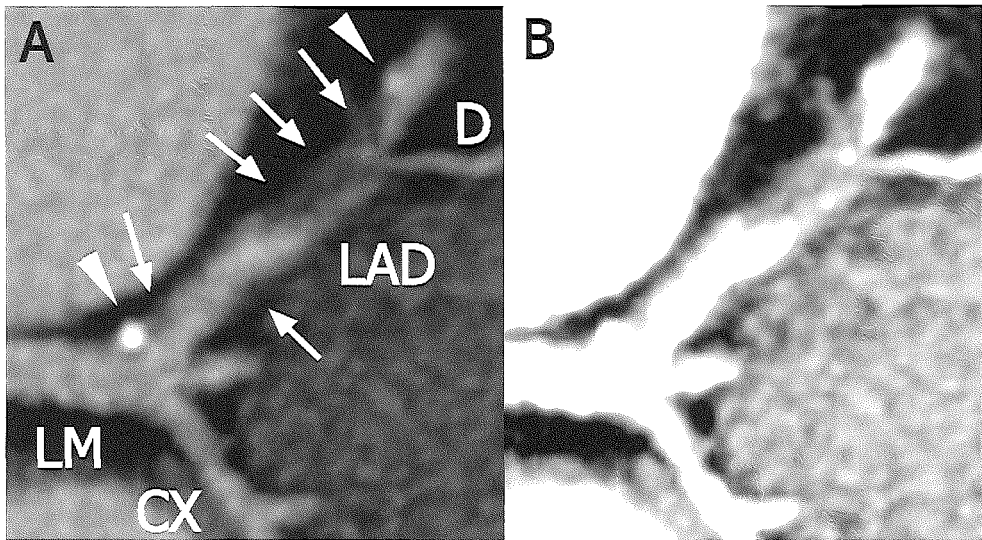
Coronary artery plaque imaging. A MSCT coronary angiogram displaying the left coronary trifurcation. At the proximal left anterior descending coronary artery (LAD) a partly calcified plaque can be observed. Non calcified plaque material can be found along the LAD. Proximal to the origin of the first septal and diagonal branches (D) a atherosclerotic lesion, largely consisting of non calcified tissue, obstructs the vessel lumen. The CT density varied between 30 and 50 HU. The CT data were acquired with a Somatom Sensation 16 (Siemens, Germany), rotation time 420 ms, detector collimation: 12 x 0.75 mm).
